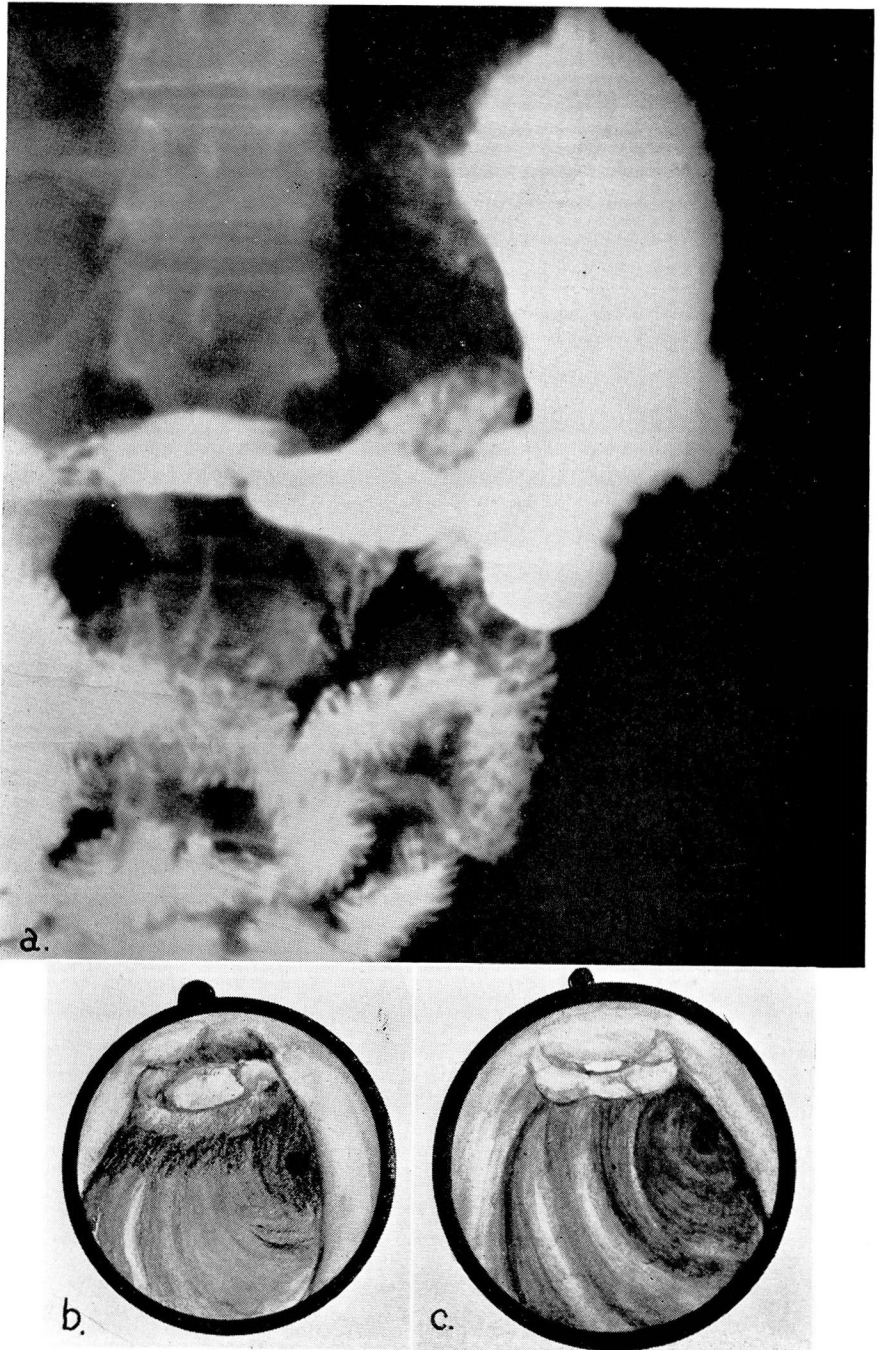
a. Normal roentgenogram.
